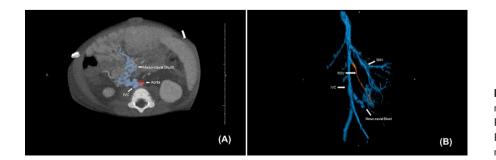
A, CT scan shows a mesocaval shunt. B, 3D reconstruction, RGV in orange. IVC, inferior vena cava; RGV, right gonadal vein; SMV, superior mesenteric vein
